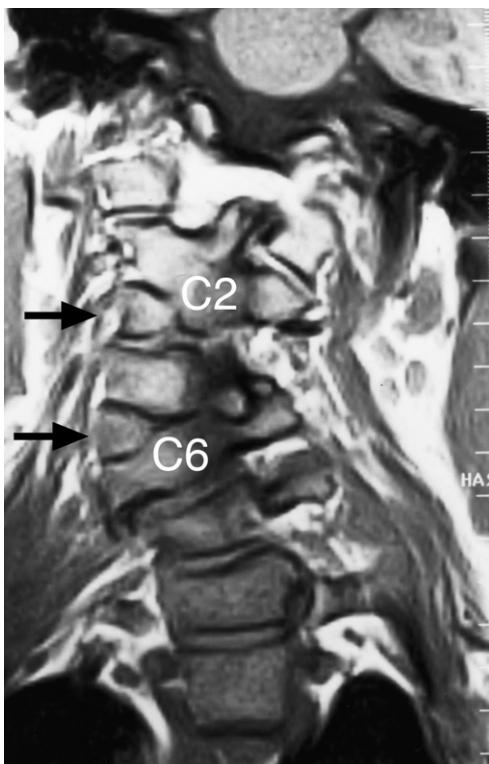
Cervical spine MRI coronal image showing some of the osseous anomalies such as the C3 and C5 hemivertebrae (arrows).
